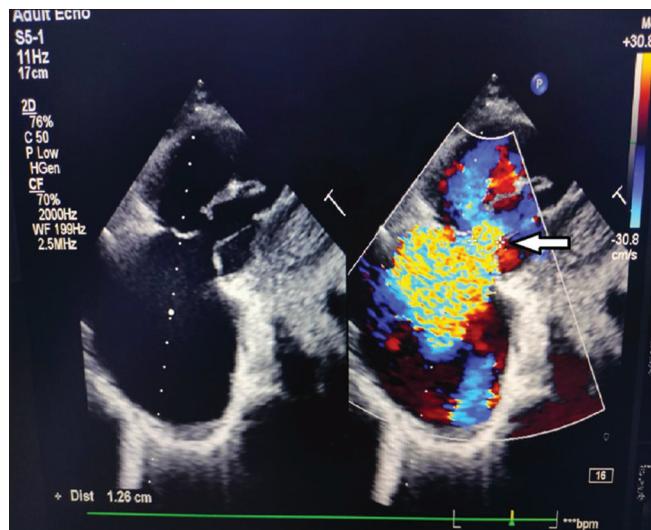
Echocardiographic image showing severe tricuspid regurgitation with a vena contracta 1.26 cm
